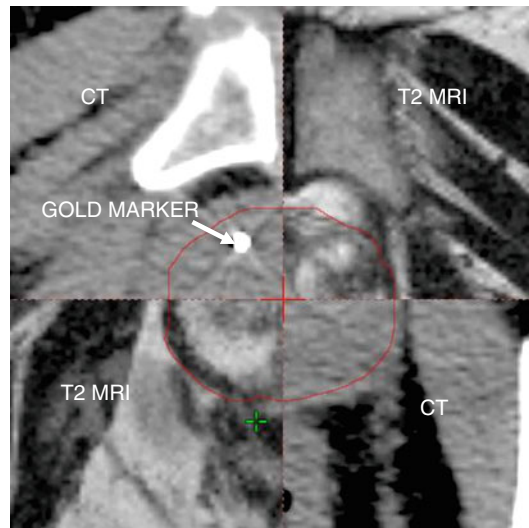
CT/MRI T2 fusion on gold markers
